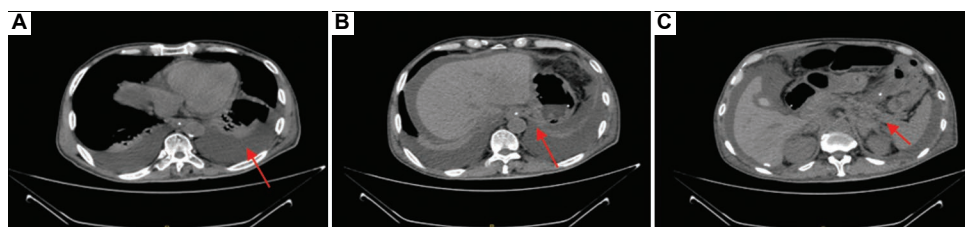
Chest and abdominal computed tomography (CT) scans. (A) Pleural effusion with atelectasis of the anterior lung tissue. (B and C) CT images of the abdomen demonstrating multiple enlarged retroperitoneal and pelvic lymph nodes suggestive of metastasis (red arrows). There is evidence of peritoneal and omental metastases, accompanied by massive ascites in the abdominal and pelvic cavities. Red arrows indicate the enlarged lymph nodes and areas of probable lymphatic compression/obstruction responsible for chylous leakage.
